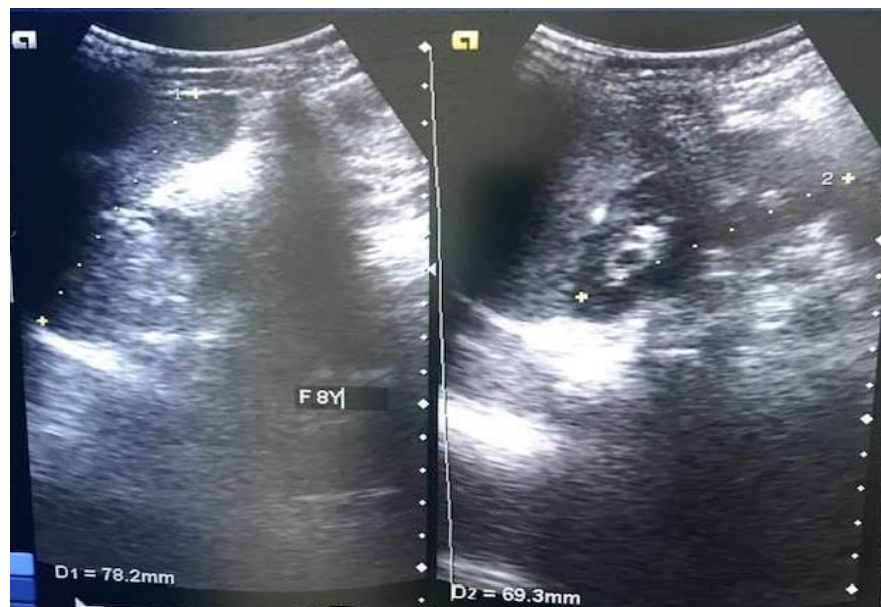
Sonogram of spleen and left kidney lengths of 8years old female child.
